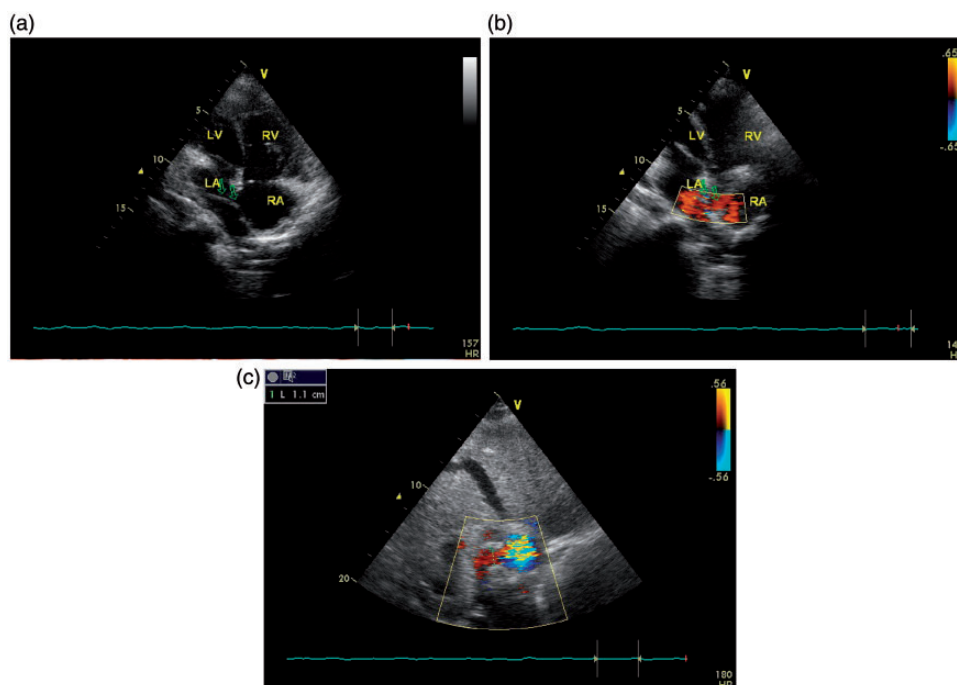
(a, b) Parasternal long-axis view of the left ventricle, showing the tunnel inside the left atrium (LA) from the additional left-sided superior vena cava to the right atrium (RA). (c) Subcostal view; the diameter of the tunnel mouth at the inflow to the right atrium was 1.1 cm.
